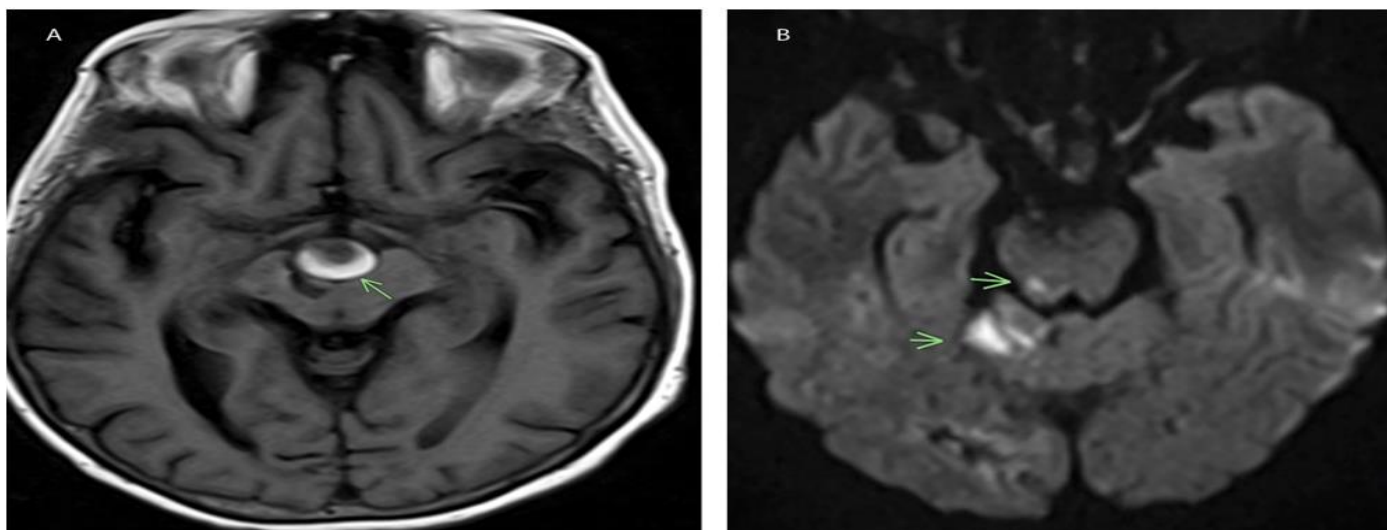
Repeat MRI. A. T1 sequence, showing altered signal characteristics and volume indicating increased size of thrombus (arrow). B. Trace sequence. New right dorsal midbrain and superior cerebellar acute infarcts demonstrated (arrows).
